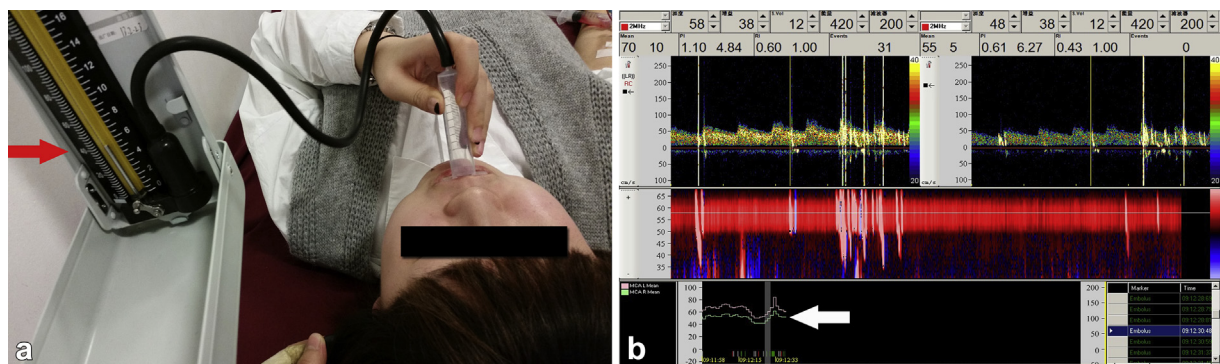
Quality control of the modified and conventional Valsalva maneuvers. (a) The red arrow points to 40 mm Hg on the sphygmomanometer. (b) The white arrow points to the Doppler flow velocity curve (first down and then up).
